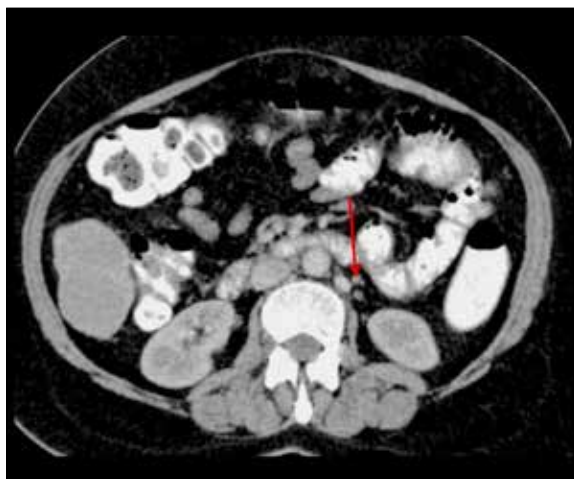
Contrast-enhanced CT scan of the upper abdomen shows multiple subcentimeter paraaortic lymph nodes (red arrow).
